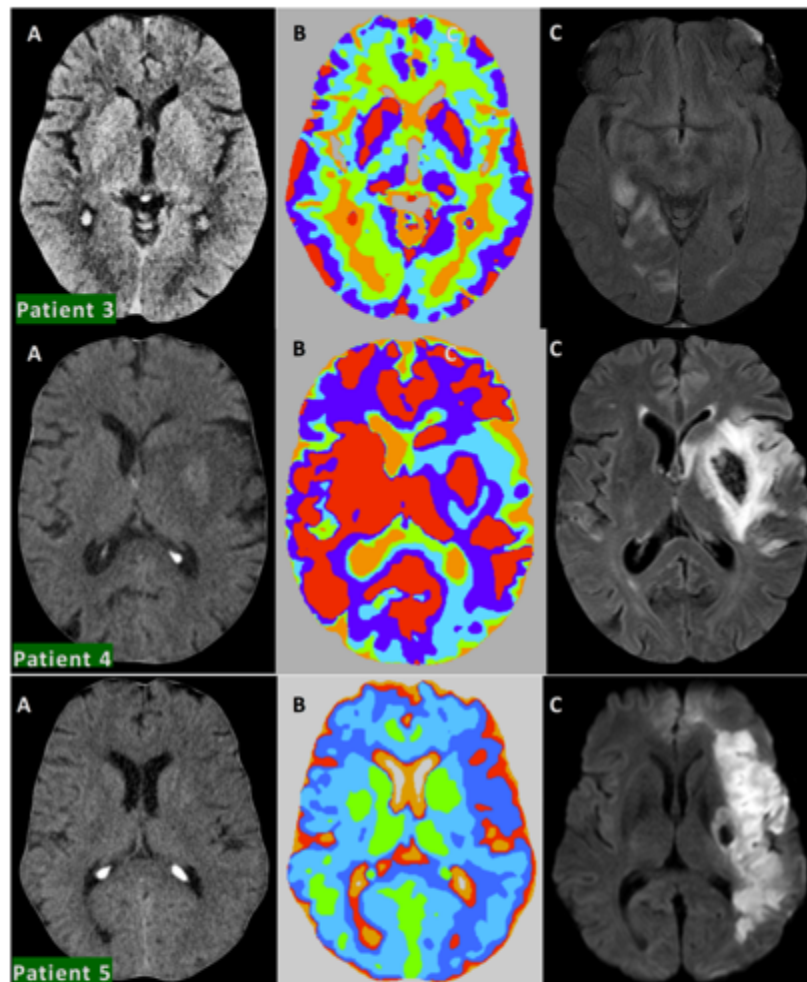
Stroke patients 3, 4 and 5, from left to right: A - original CT, B - clustering results after triple filtering and C - FLAIR MRI showing the infarct location
